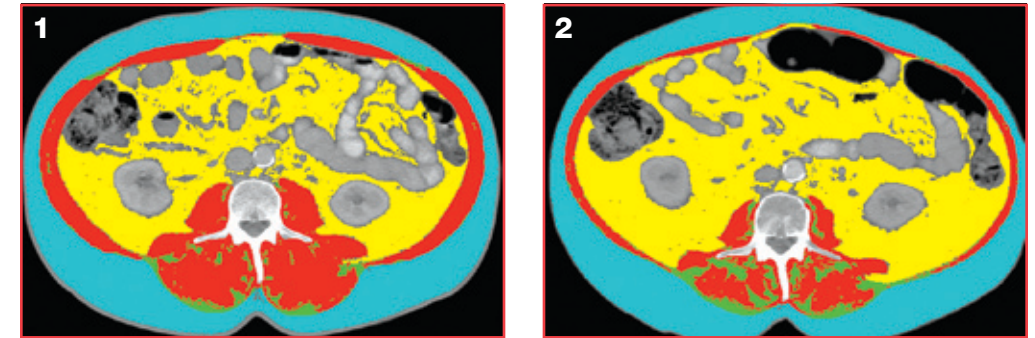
Skeletal muscle loss in a patient with lung cancer. Segmented CT images for a male lung cancer patient at two separate timepoints. Number 1 was taken 390 days before death, and 2 was taken 58 days before death. Segmented tissues of interest: ■ is skeletal muscle, ■ is visceral adipose tissue, ■ is subcutaneous adipose tissue, and ■ is intramuscular adipose tissue. During this 332-day period, skeletal muscle area decreased from 173 cm² to 86.7 cm².
